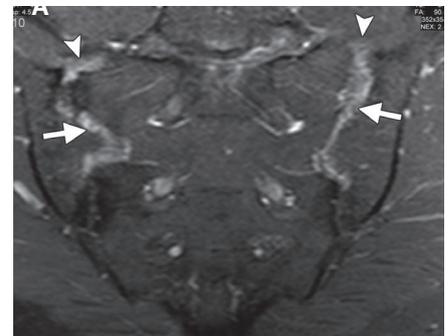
Inflammatory sacroiliitis and spondylodiskitis. Coronal oblique fat-suppressed T1-w MR images obtained before (a) and after (b) the administration of paramagnetic contrast medium show marked irregularity and several erosions of both sacroiliac joints (arrows in a, white arrows in b), as well as a large erosion on the superior S1 endplate (arrowhead). Note the enhancement of the synovial portion of both joints (black arrows in b), a finding that is consistent with synovitis, and the enhancement of the S1 endplate erosion.
